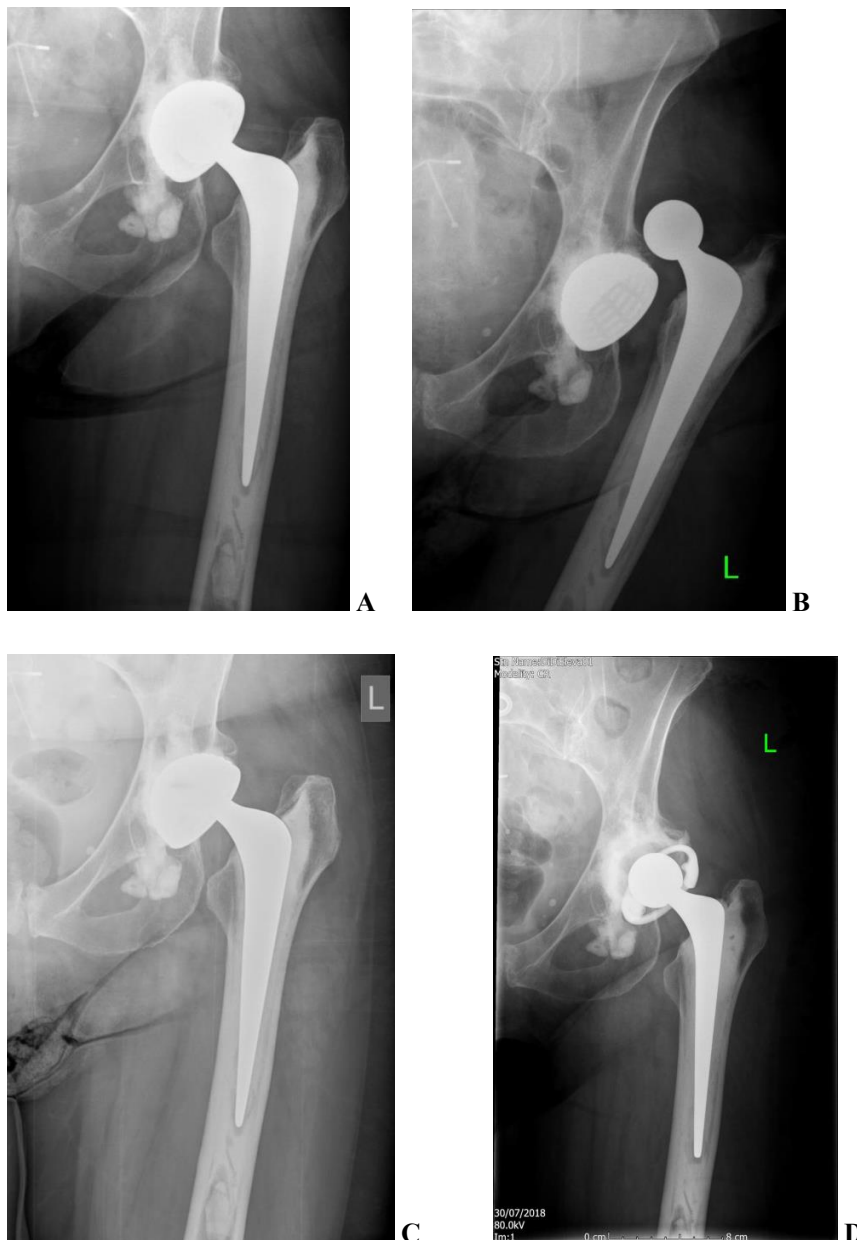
Intra-prosthetic disarticulation at 3 years following left revision SERF cemented Novae Stick dual mobility cup (A – before dislocation episode) – The hip before (B) and after (C) closed reduction under sedation had been performed in the Emergency Department. Note the asymmetric reduction, indicating that the polyethylene component (not easily seen on this radiograph) had become detached from the metal head of the femoral prosthesis. This was revised using the cement-in-cement technique to a constrained liner (D).
